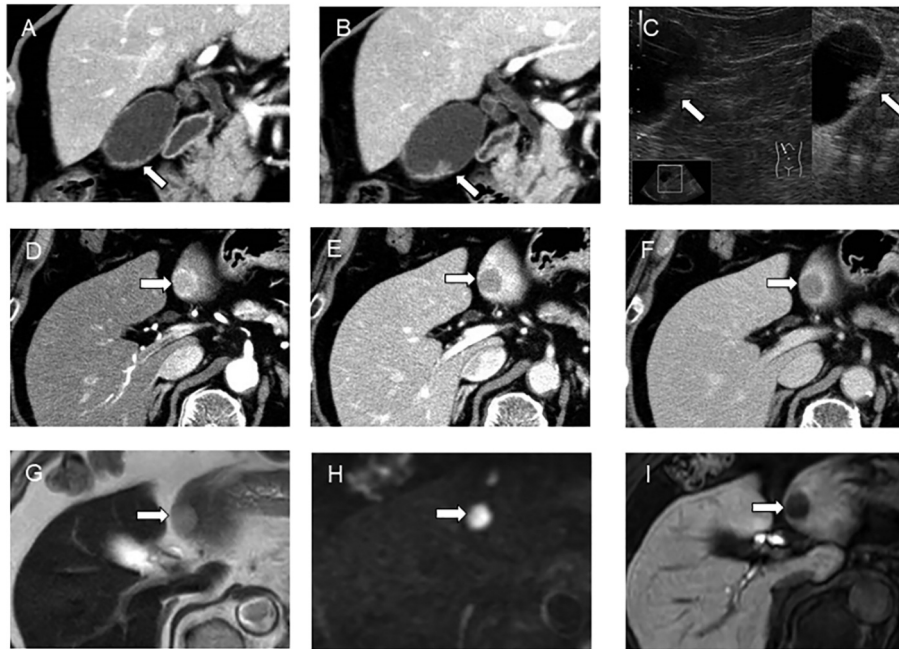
Preoperative diagnostic images. Contrast-enhanced computed tomography (CT) coronal images in the portal venous phase showing the gallbladder tumor that tended to increase in diameter (A, B). Contrast-enhanced ultrasonography shows a mulberry-type enhanced lesion in the gallbladder on the vascular phase (C). Abdominal CT images of the liver tumor (D-F). The tumor showed an early ringed enhancement (D) with prolonged peripheral enhancement (E, F) during the arterial phase to equilibrium phases. Magnetic resonance (MR) images (G-I). T2-weighted MR image shows a mildly hyperintense tumor in the lateral segment (G). Diffusion-weighted image shows hyperintensity; the mean apparent diffusion coefficient was calculated as $1.1 \times 10^{-3} \text{ mm}^2/\text{s}$ (H). Gadolinium-ethoxybenzyl-diethylenetriamine pentaacetate MR images of the hepatobiliary phase are hypointense (I). Tumor is indicated by an arrow.
